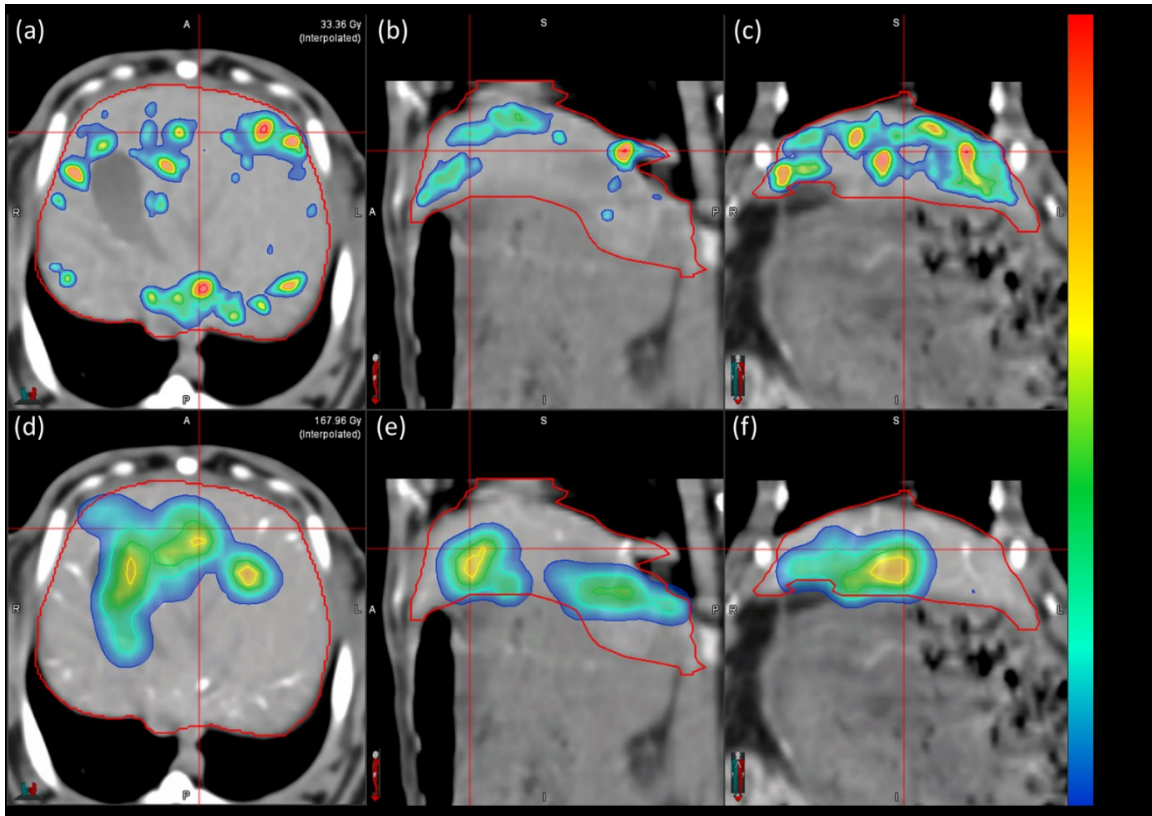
(a-c) Axial, sagittal, and coronal views of the CT-based dose distribution DD_{CT} in R05 overlaid on an axial CT [HU: -100 to 200]. (d-f) Axial, sagittal, and coronal views of the PET-based dose distribution DD_{PET} in R05 overlaid on an axial CT [HU: -100 to 200].
